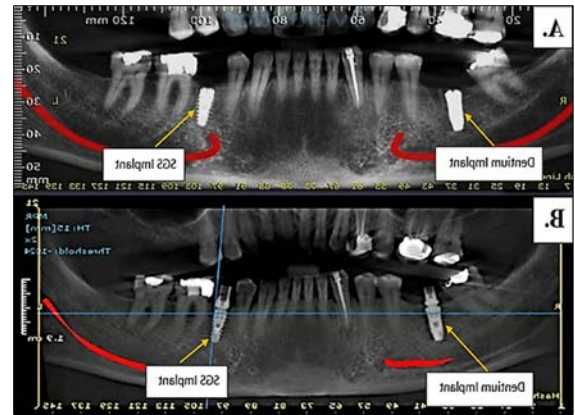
CBCT (Panoramic View) of implants both SGS and Dentium. A. After 2-weeks post-operatively. B. Implants with abutments after 4 months post-operatively.
